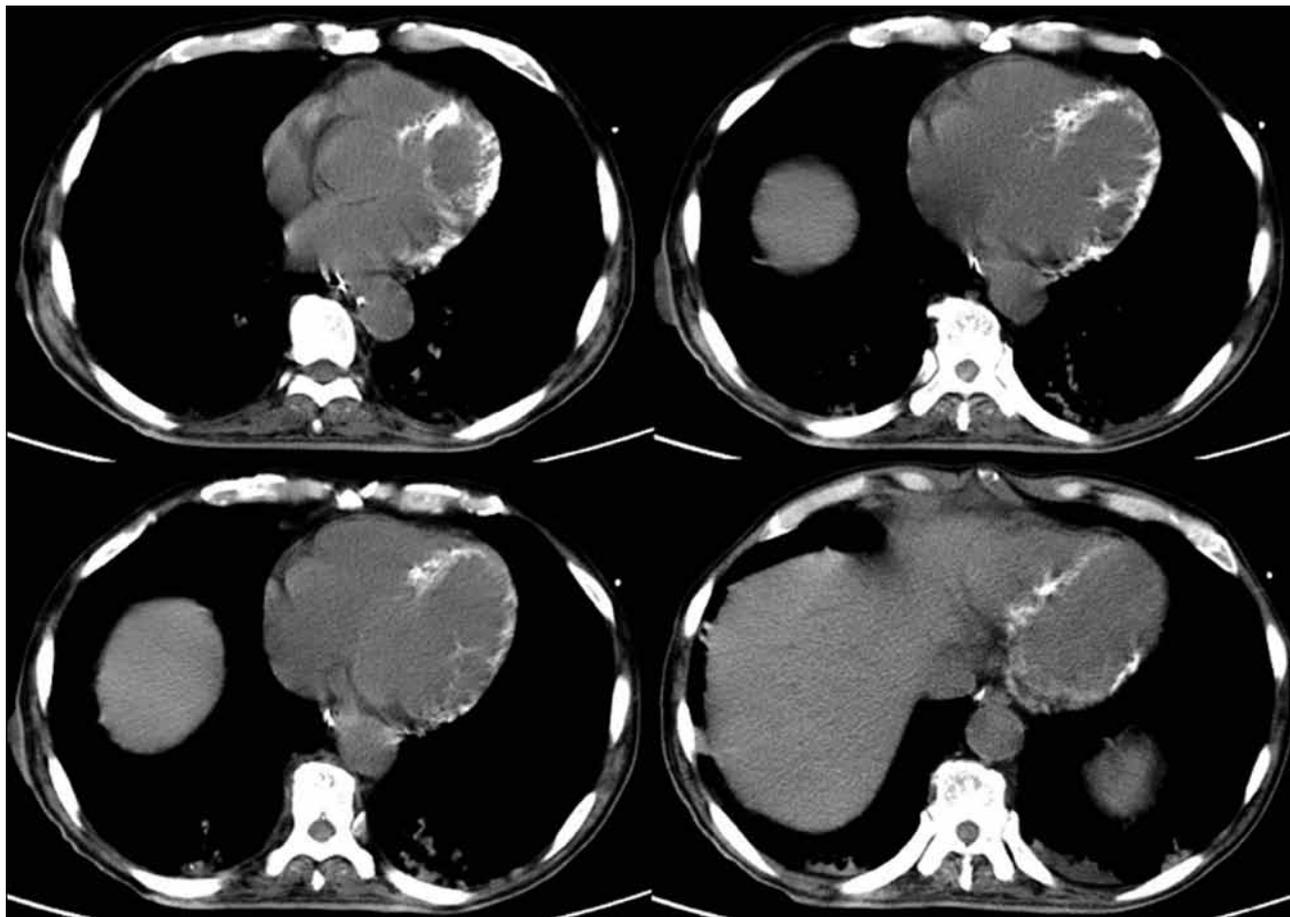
Postoperative non-contrast computed tomography: serial axial slices through the left ventricle of the heart showing thick, linear calcification in the myocardium of the left ventricle.
